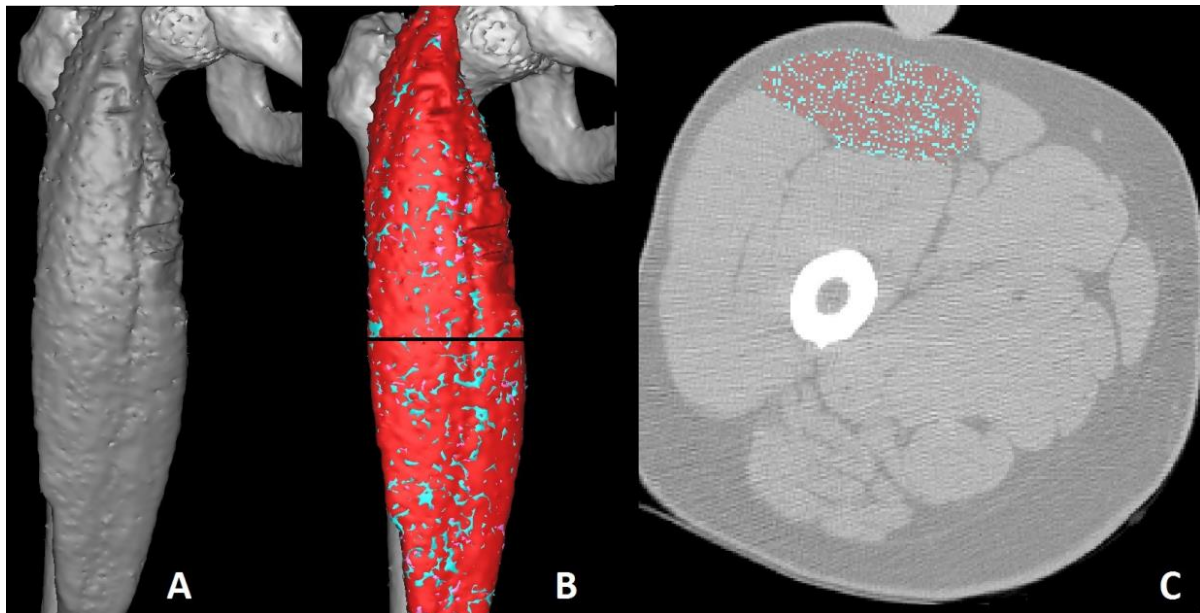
3D false-color CT reconstruction of a *Rectus femoris* muscle from a healthy patient, including the epimysium at the cortical level in A) gray and B) false colors, along with C) the corresponding cross-section at mid-belly. The total volume is  $4.2 \times 10^5$  mm<sup>3</sup>, and from this volume, 3% is fat [-200; -10] HU, 28.7% is loose connective tissue and low-density (atrophied) muscle [-9; 40] HU, and 68.3% is normal muscle [41; 200] HU.
